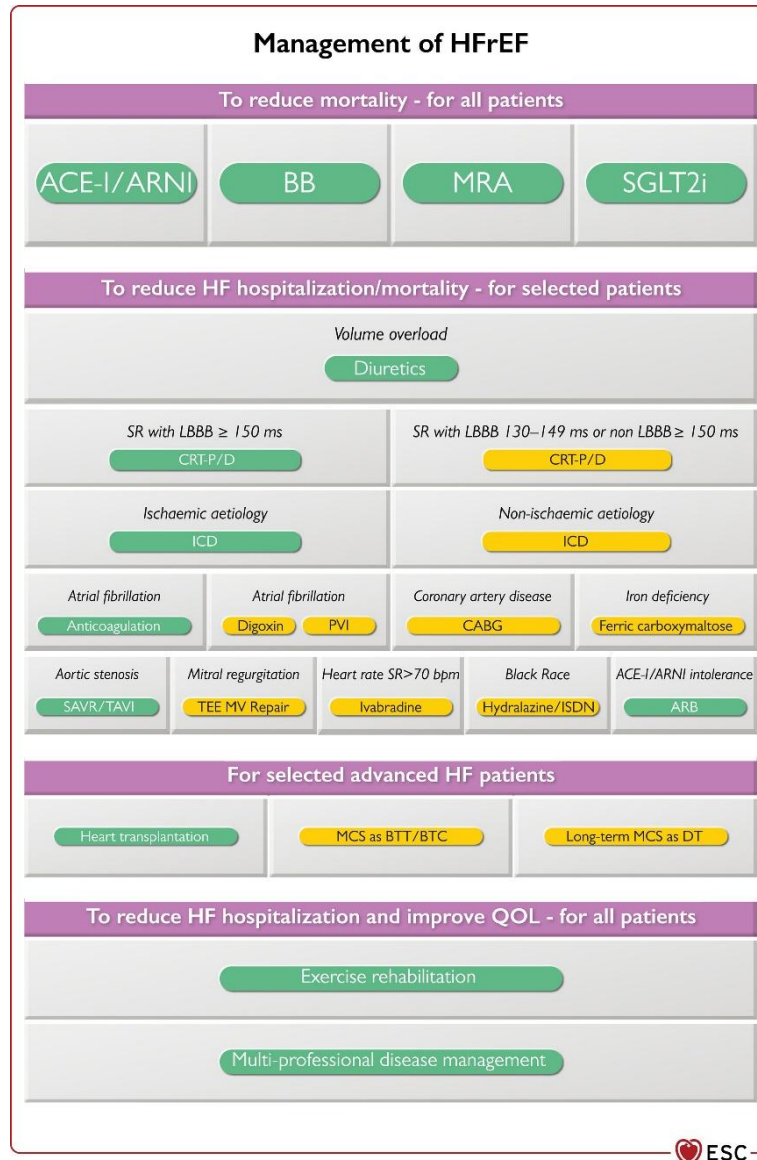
Phenotypic-based management algorithm for heart failure with reduced ejection fraction (HFrEF). HF (heart failure); HFrEF (heart failure with reduced ejection fraction); ACE-i (angiotensin-converting enzyme inhibitor); ARNI (angiotensin receptor-neprilysin inhibitor); BB (β -blocker); MRA (mineralocorticoid receptor antagonist); SGLT2i (sodium-glucose co-transporter 2 inhibitor); SR (sinus rhythm); LBBB (left bundle branch block); CRT-P/D (cardiac resynchronization therapy pacemaker/defibrillator); ICD (implantable cardioverter-defibrillator); PVI (pulmonary vein isolation); CABG (coronary artery bypass graft); SAVR (surgical aortic valve replacement); TAVI (transcatheter aortic valve implantation); TEE (transoesophageal echocardiography); MV (mitral valve); ISDN (isosorbide dinitrate); ARB (angiotensin receptor blocker); MCS (mechanical circulatory support); BTT (bridge to transplantation); BTC (bridge to candidacy); DT (destination therapy); QOL (quality of life)¹
